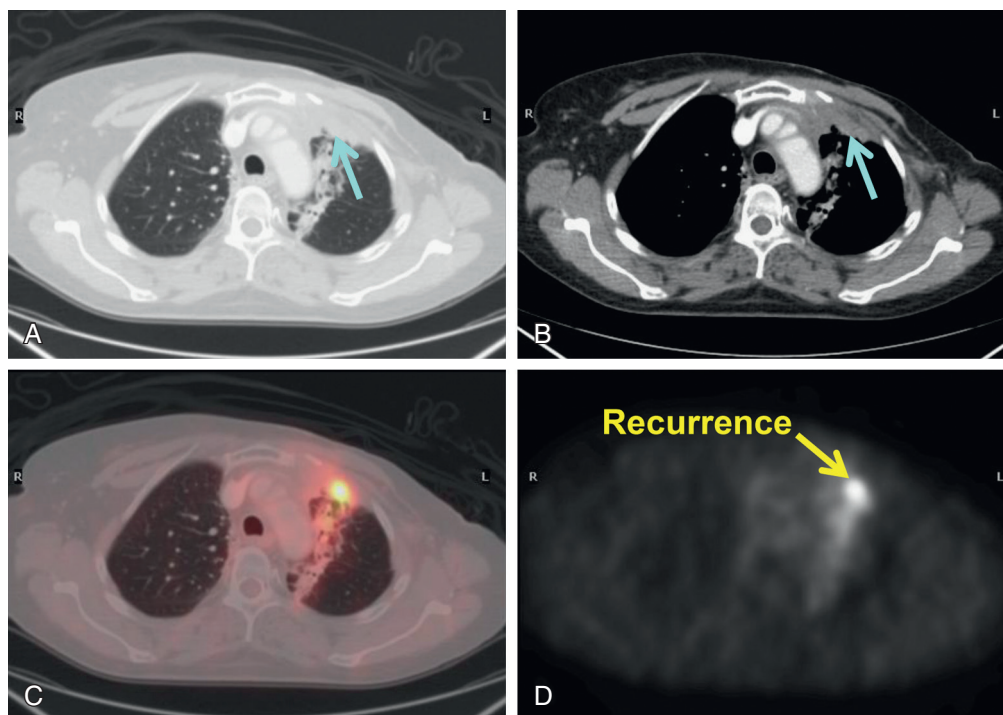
Recurrence following radiation therapy. Contrast-enhanced CT (with lung (A) and soft-tissue (B) windows) demonstrates opacity in the left upper lung in a geographic distribution consistent with postradiation therapy changes. Fused PET/CT (C) and PET (D) images reveals expected mild activity within the radiation treatment field, but superimposed focal activity (arrow) on FDG-PET corresponding to a focal area of nodular pleural thickening on CT (light blue arrows) which was subsequently shown to represent recurrent tumor.
